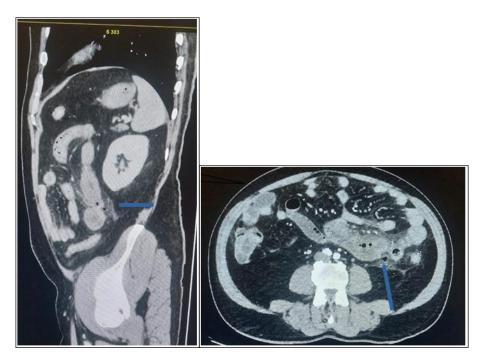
Contrast-enhanced CT image shows jejunal diverticula as round, thin-walled structures with no recognizable folds. Note gas within peritoneal cavity and infiltration of perijejunal fatty tissue.
